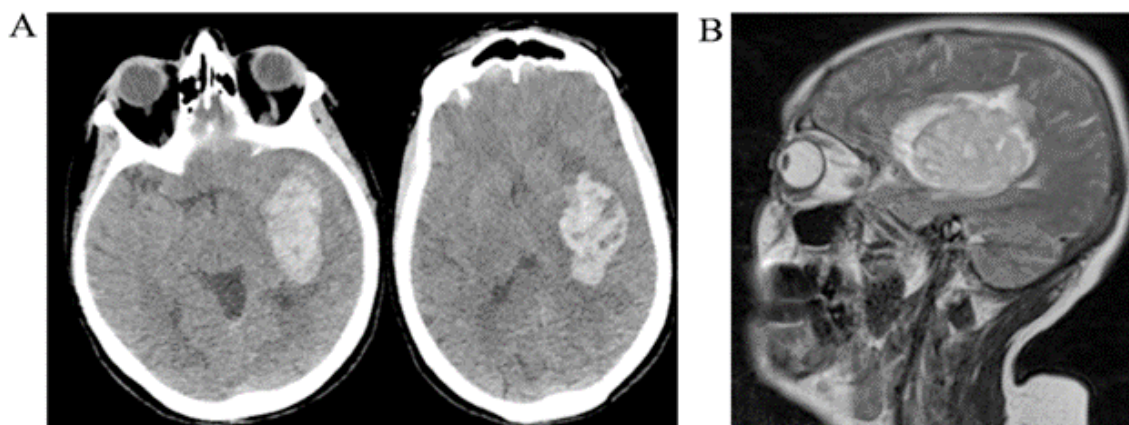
A) Pre-operative CT: left lateral ventricle compression of left hemisphere bleeding area-right lateral ventricle compression with shifting effect, B) Pre-operative Sagittal Section MR: left lateral hemisphere bleeding area with large oedema around it.
